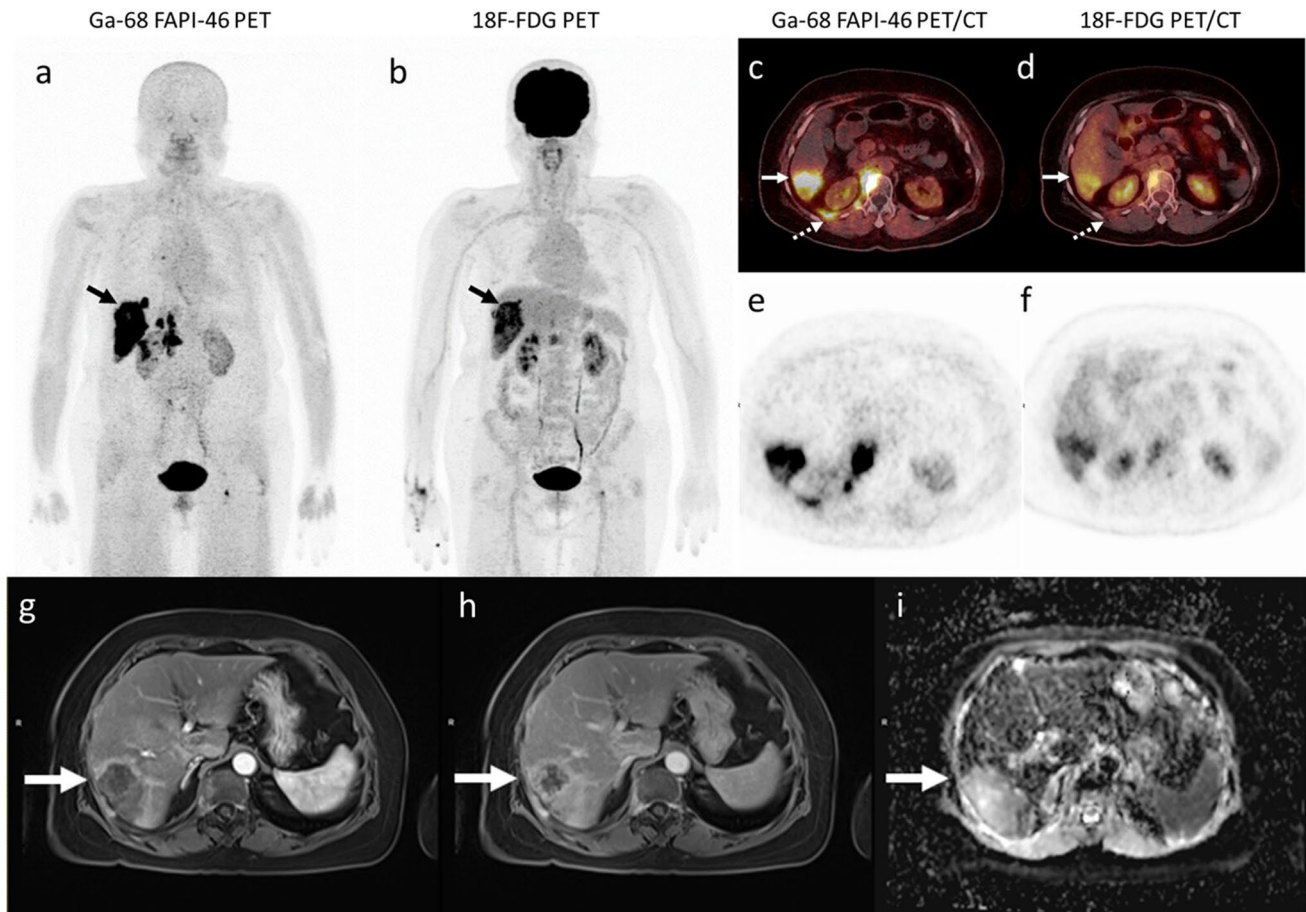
A 62-year-old woman with intrahepatic cholangiocarcinoma underwent PET/CT with dedicated liver PET/MRI for initial staging. (a) MIP image of [⁶⁸Ga]Ga-FAPI-46 PET, (c) fused axial [⁶⁸Ga]Ga-FAPI-46 PET/CT image, and (e) axial [⁶⁸Ga]Ga-FAPI-46 attenuation correction PET image show a lesion with intense uptake (SUV_{max}=24.02, TBR=21.07) in the liver (arrows) corresponding to the primary liver cancer. (b) MIP [¹⁸F]FDG PET image, (d) fused axial [¹⁸F]FDG PET/CT images, and (f) axial [¹⁸F]FDG PET attenuation-corrected PET image show less tracer uptake than [⁶⁸Ga]Ga-FAPI-46 PET (SUV_{max}=15.79, TBR=4.97) in the corresponding liver lesions (arrows). The corresponding axial MR images show a mass in hepatic segments VI/VII with adjacent intrahepatic bile duct dilatation. This lesion shows delayed enhancement (g, h) and restricted diffusion on (i) DWI/ADC images.
